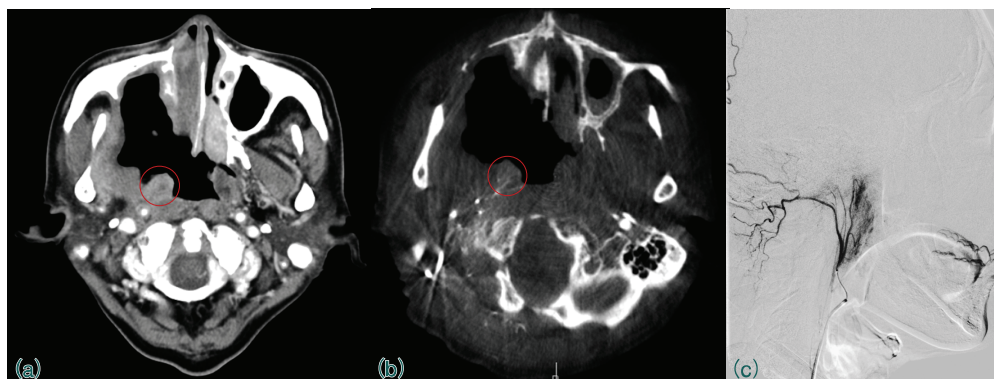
CT-Like Imaging of the Neck in Arterial Infusion Therapy
